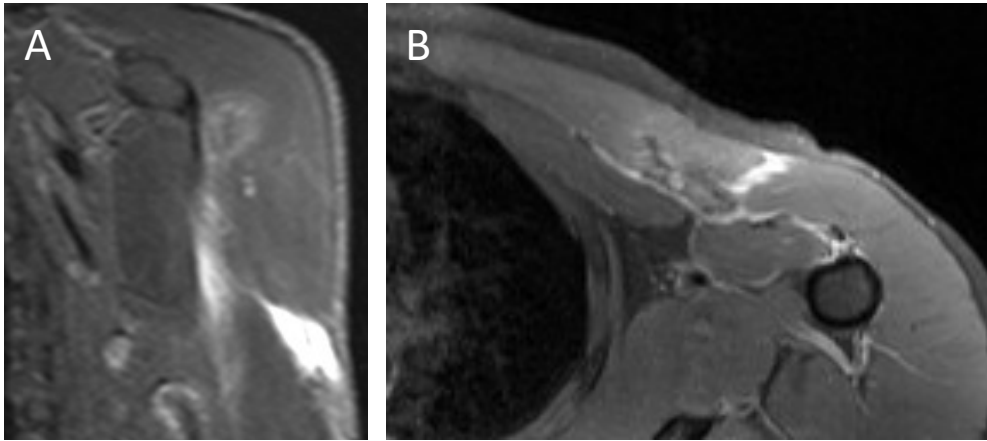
Smoke sign on coronal short tau inversion recovery sequence with sharp medial margins of the edema adjacent to the coracobrachialis/short head of biceps and irregular lateral margins. B: PD weighted fat saturated transverse pectoralis MRI demonstrating the pectoralis tendon tear.
